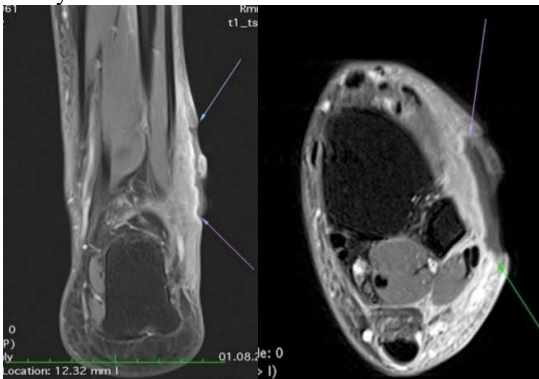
MRI of the left ankle showing necrotic and suppurative lesion in the subcutaneous adipose tissue
